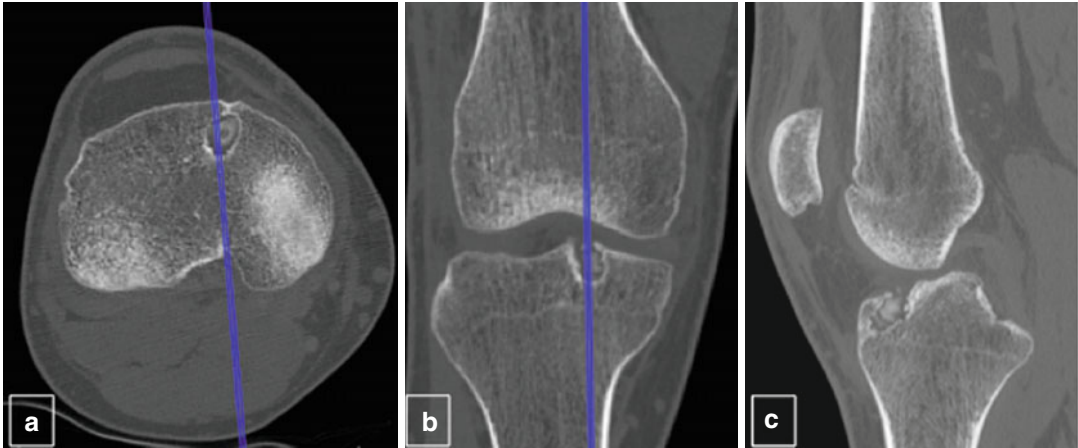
CT scan with axial (a), frontal (b) and sagittal (c) view. In this case, the tibial tunnel is too anterior
